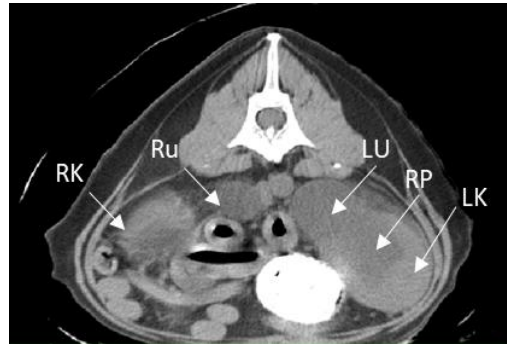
CT image of the right and left kidneys and ureters: RK – right kidney, RU – right ureter, LK – left kidney, LU – left ureter, RP – renal pelvis.
